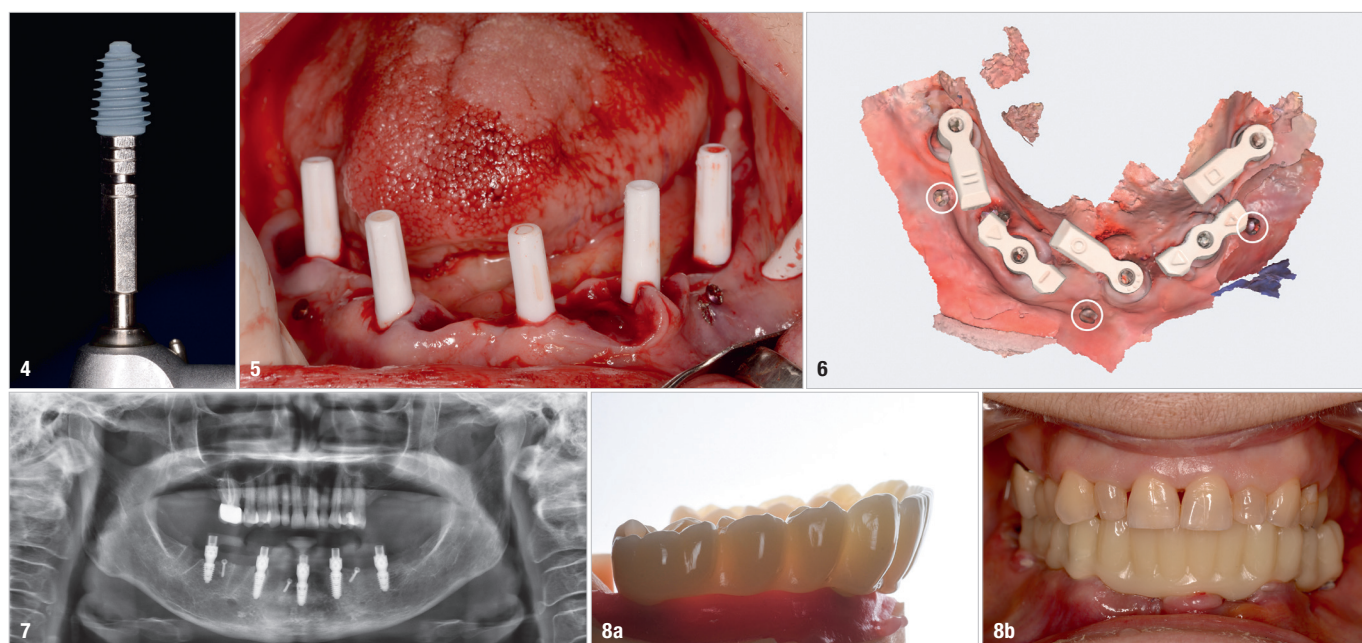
AnyRidge implant. Fig. 5: Intra-op photograph after attachment of the osteosynthesis screws and implant placement. Fig. 6: Post-op scan with SmartFlags and osteosynthesis screws (circled). Fig. 7: Panoramic radiograph for scan body verification. Figs. 8a & b: Screw-retained PMMA provisional restoration (a). Delivery of the provisional restoration the day after the surgery (b).
